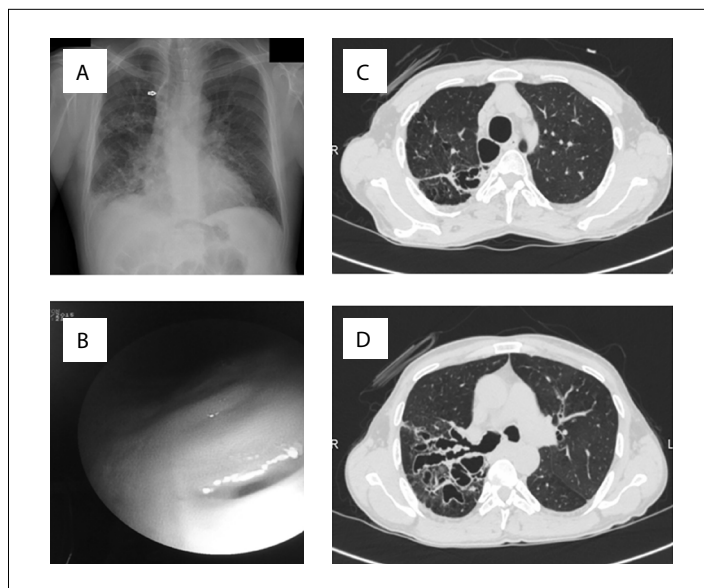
A. Chest X-ray showing ill-defined opaque areas, reticular dense areas and cystic lesions, predominantly in the right middle and lower zone; and also right paratracheal lucency (arrow). B. Diverticulum orifices on the tracheal wall seen in bronchoscopy. C and D. Chest computed tomography showing dilated trachea and bilateral main stem bronchi diverticula arising from the intrathoracic trachea; bilateral cystic bronchiectasis presenting predominantly in the right middle and lower lobe.
